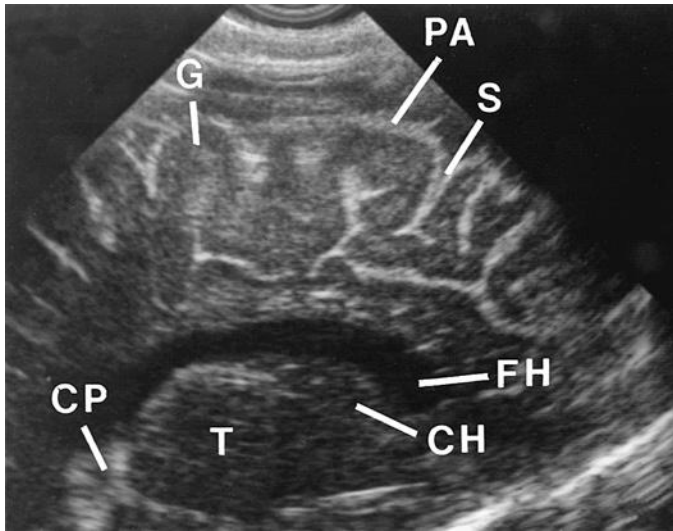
Parasagittal sonogram of the brain of a 6-month-old child. Gyri (G) are well developed. Pia-arachnoid (PA) tissues cover the surface of the brain and make the sulci (S) highly conspicuous. Careful inspection of gyri shows that cortical “gray matter” is less echogenic than the “white matter” (this is almost certainly not a difference due to gray and white matter distinction but to the vessels coursing through the central gyrus). CH, caudate head; CP, choroid plexus; FH, frontal horn; T, thalamus.
